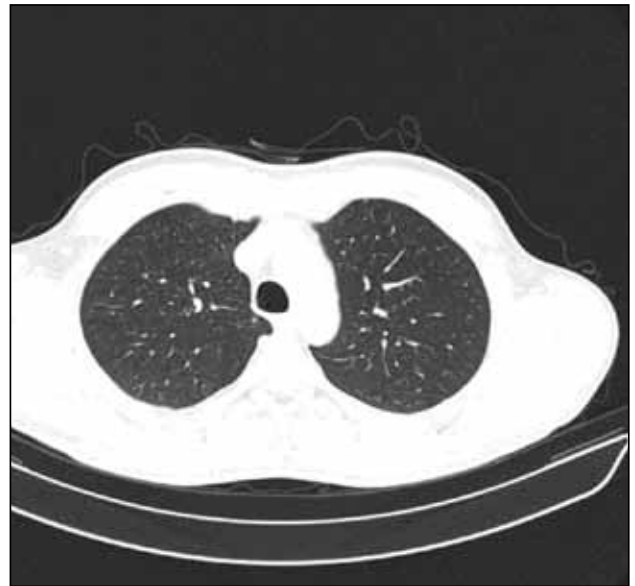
Chest CT scan, axial slice - mediastinal lymphadenopathy and micronodules distributed bilaterally throughout both lungs.
